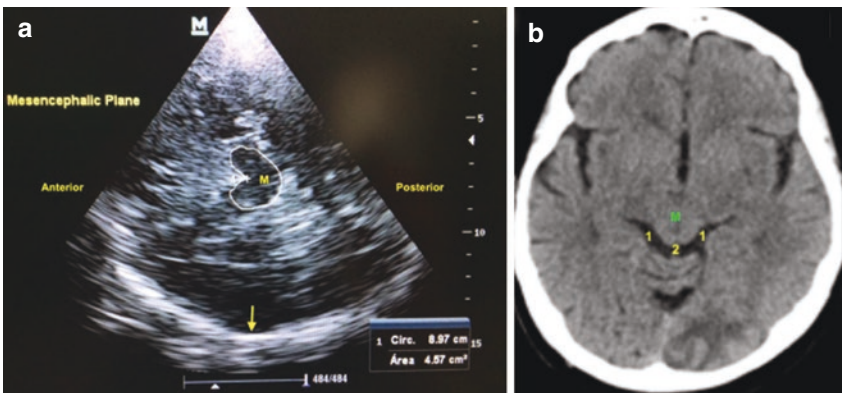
(a) Mesencephalic plane by TCCS: (M) mesencephalon; (arrow) contralateral skull. (b) Brain anatomy by CT scan: (M): mesencephalon; (1) ambient cistern and (2) quadrigeminal cistern. (Author: Camilo N. Rodríguez)
